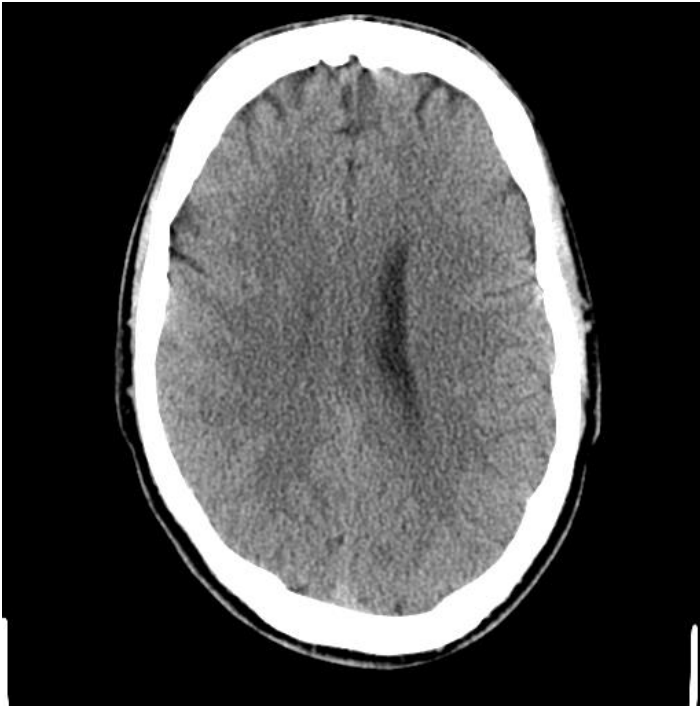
Cerebral oedema (CT scan)
